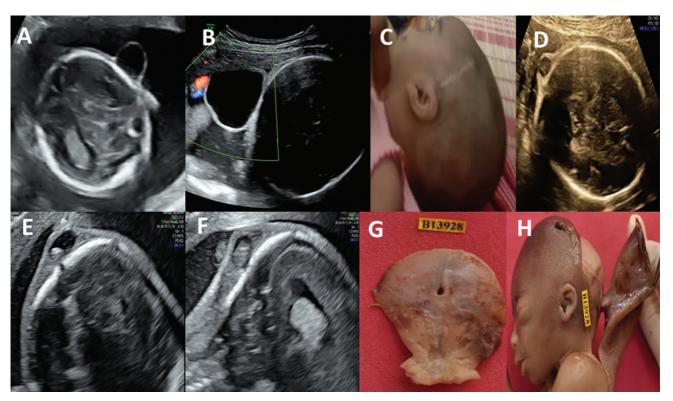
(A–C) Case 1: (A) Transabdominal ultrasound image of the fetal head at 18.2 weeks showed a 1.4×1.2 cm cystic structure in the left temporal region above and anterior to the left ear. Intracranial anatomy was normal. (B) At 32 weeks, the cyst increased, measuring 4.9 × 3.4 cm. (C) Postnatal surgical excision done at day 35, small intracranial communication was excised. (D) Case 2: Transabdominal ultrasound image of the fetal head at 27.5 weeks showing 1.2×0.7 cm thick walled cystic lesion with echogenic material is seen in the scalp of the occipital region with normal intracranial anatomy and head circumference. (E-H) Case 3: (E, F) High frequency transvaginal ultrasound image of fetal head showing small rent in the occipital bone with herniation of meninges seen measuring 0.9×0.7 cm. Head circumference was falling at the 5th centile. (G, H) Autopsy images revealed a tiny calvarial defect of 2 mm size with herniation of meninges.
